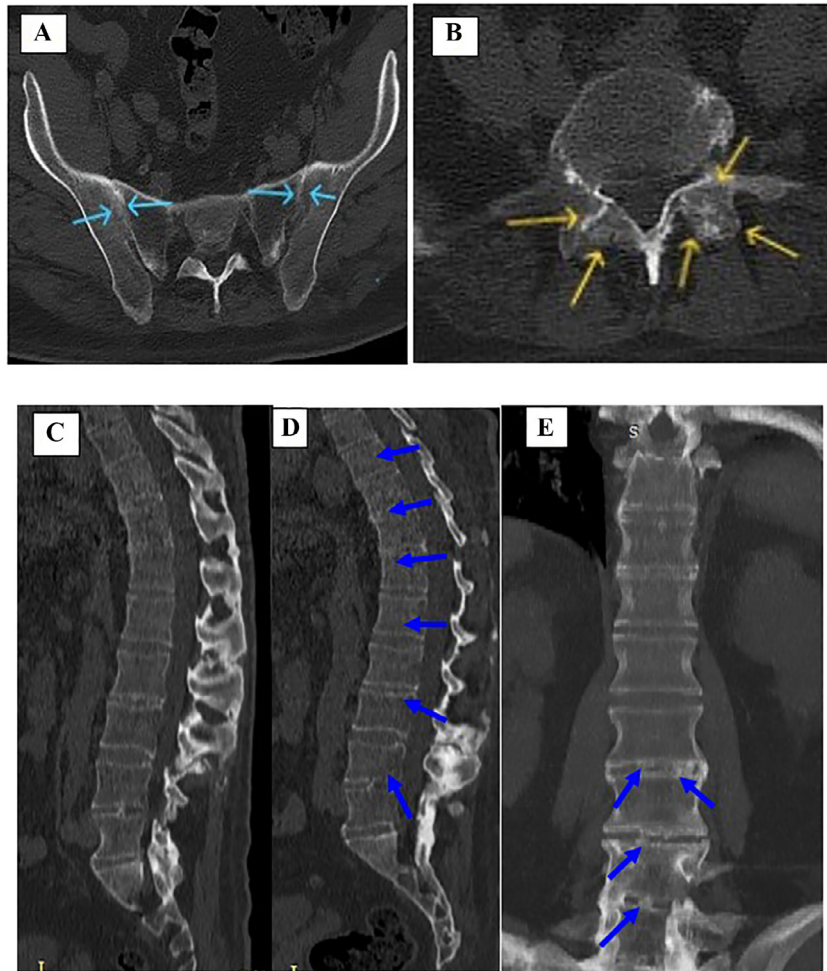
CT images: (A) CT of the pelvis in the axial projection of the sacroiliac joint, blue arrows show subchondral sclerosis and narrowing of the bilateral joint spaces, particularly on the right side. (B) CT of L5 vertebra in axial projection, yellow arrows indicate bilateral arthrosis. (C and D) CT in the sagittal projection of the thoraco-lumbar spine, blue arrows indicate calcifications (ossifications) of the supra and interspinous ligaments from Th9 to L5. (E) CT in the coronal section of the thoraco-lumbar spine shows the intervertebral spaces L2-L3, L3-L4 and L4-L5 with content of syndesmophytes.
